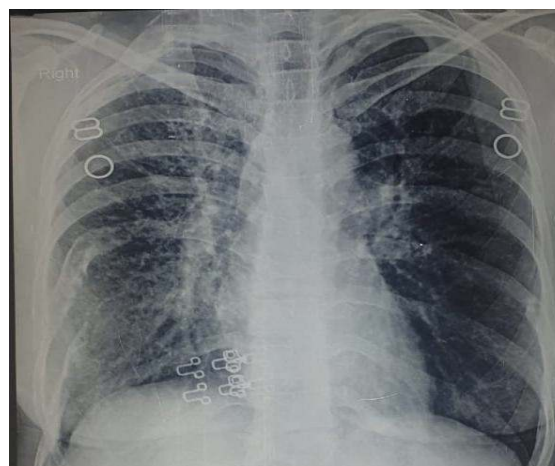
Chest x-ray: reticular opacity in right upper lobe and left hilar prominence
